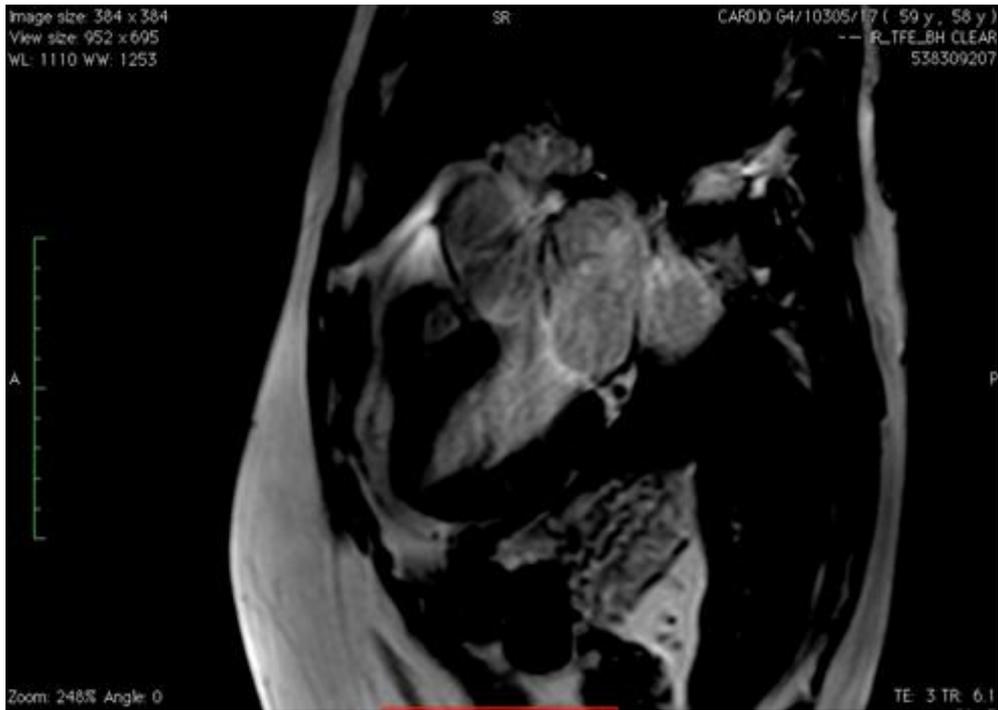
MRI section 2 cavities in late enhancement sequence 10 minutes after Gadolinium injection showing no contrast enhancement
